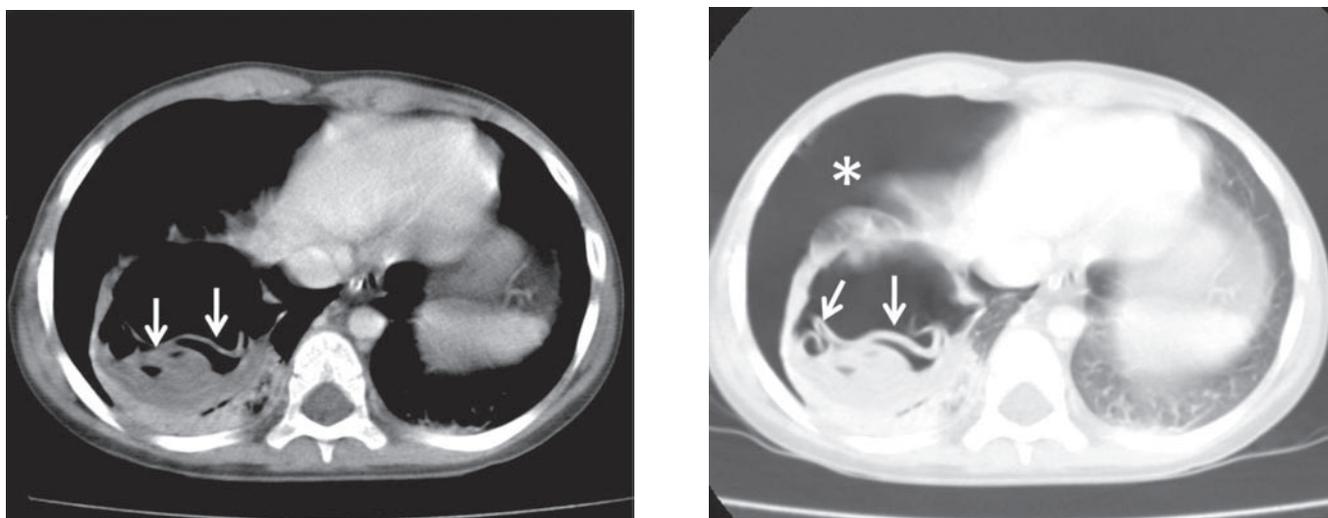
CT of thorax axial images in soft tissue (A) and lung (B) window demonstrate ruptured lung hydatid cyst. Detached membranes (arrows) and fluid collections and right sided pneumothorax (asterisk) is visible.
